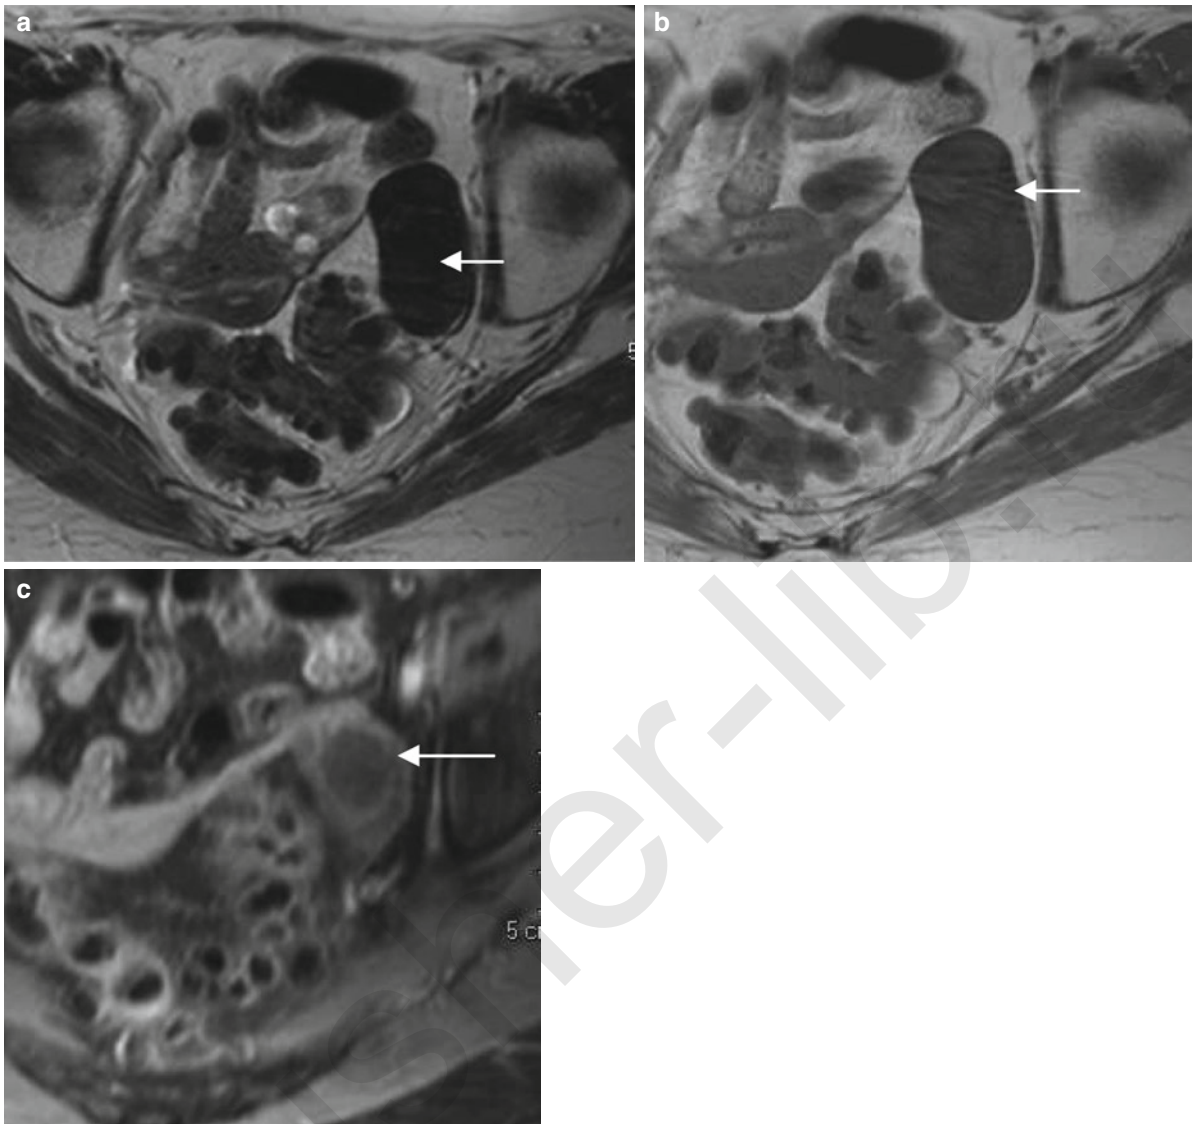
Fibrothecoma in a post-menopausal patient with vaginal bleeding. MRI demonstrates a consistently low signal, well defined, homogenous left adnexal mass on both T2W (a) and (b)
